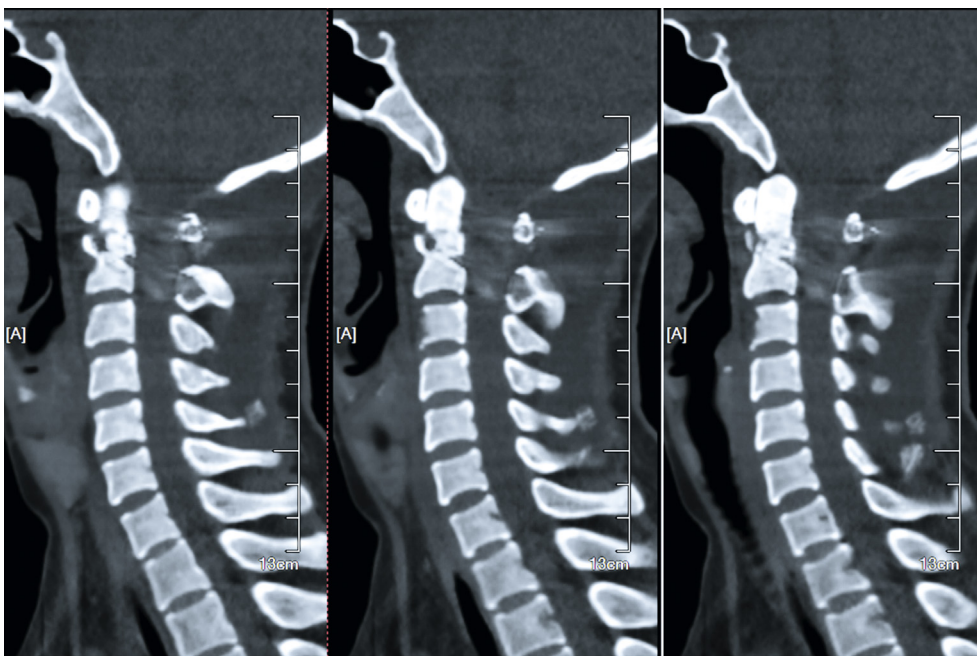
The postoperative computed tomography scan showed odontoid comminuted fracture.
